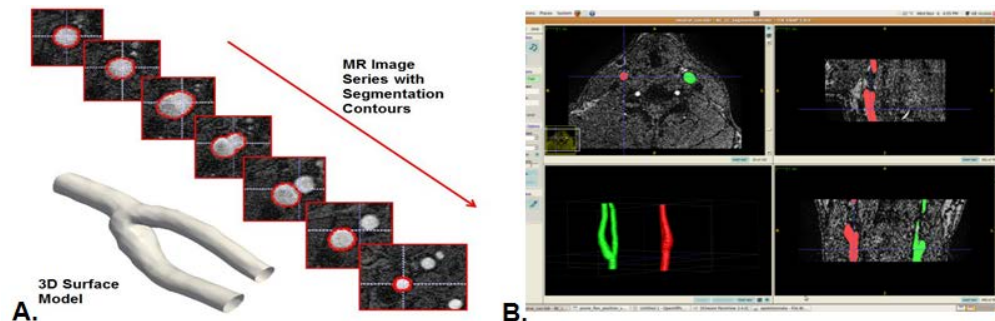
(A) MR image series with the segmentation contours and the resultant CB model. (B) Segmentation of Right (red) and Left (green) CB. The screen layouts are, top left Axial orientation, top right Sagittal, bottom right Coronal, and bottom left window represents the 3D models.
